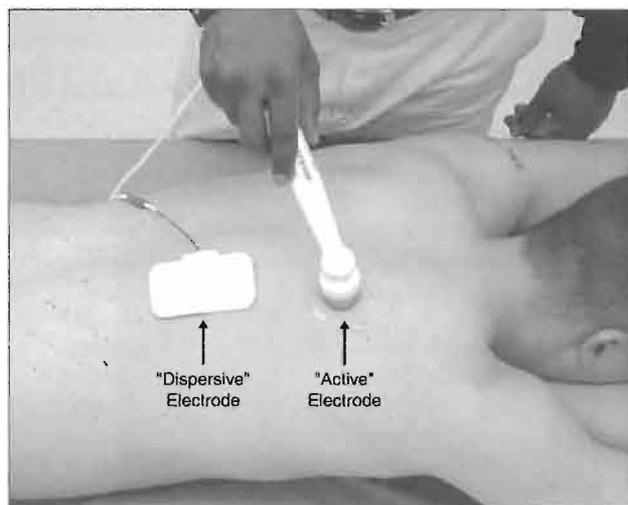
Ultrasound and Electrical Stimulation Combination Therapy. Using a sound/stimulation combination unit, one electrode is attached to the patient's body while the ultrasound head serves as the active "probe" electrode.
